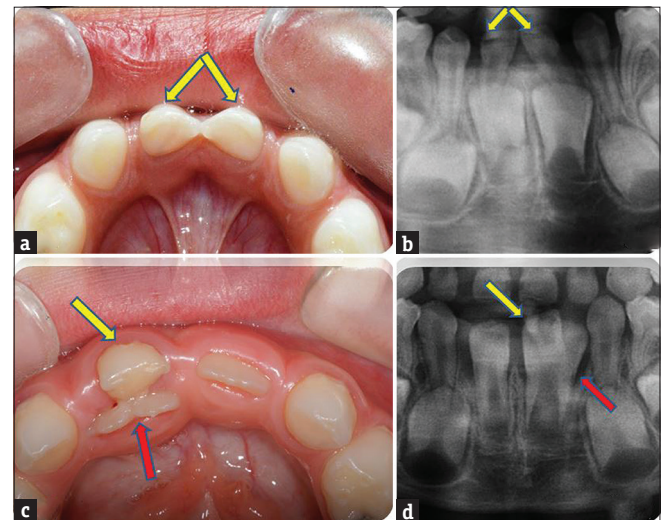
Intraoral view of bilaterally (a) and unilaterally (b) (patient 32) primary double teeth involving mandibular central and lateral incisors and a cropped orthopantomogram revealing fused primary double teeth and fused corresponding permanent mandibular central and lateral incisors (c and d). Cropped orthopantomogram of patient 32 showing the absence of the mandibular lateral incisor and a normal shaped mandibular central incisor
